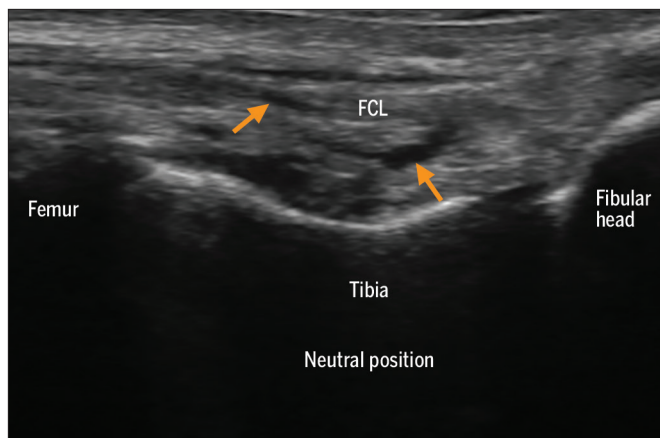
Long-axis ultrasound image of the fibular (lateral) collateral ligament (FCL) of the knee at rest in 0° of flexion. The injured ligament shows inconsistency of thickness, along with small hypoechoic foci suggestive of ligament disruption and fluid.
